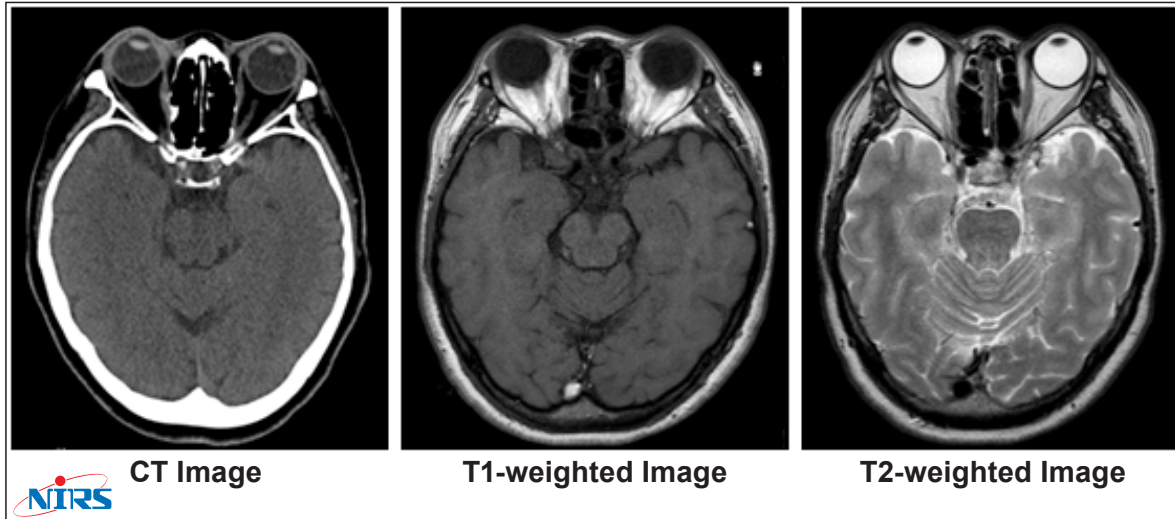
Comparison of cranial CT and MRI imaging
